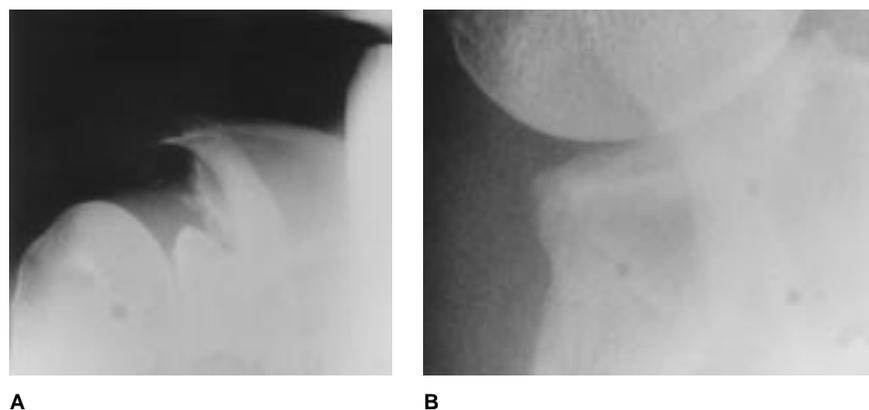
A, Standing anteroposterior 30-degree tilt radiograph of a patient with continued pain after two arthroscopic acromioplasties and one distal clavicle excision. Physical examination findings were consistent with anterior subluxation. B, Stryker notch view revealed calcification at the inferior glenoid margin.
